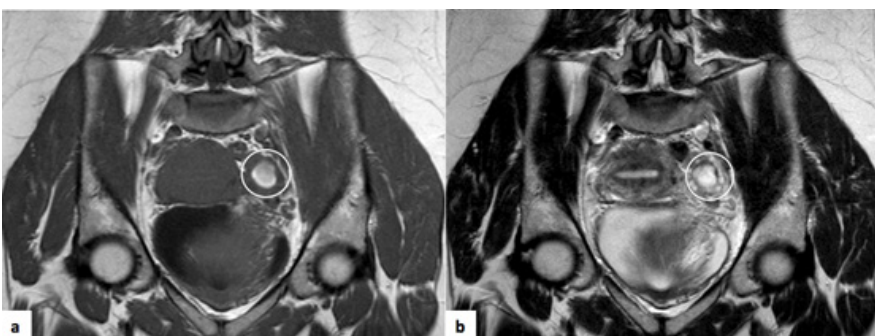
Haemorrhagic cyst. Pelvic MRI of a 33-year-old woman. (a) Coronal T1-weighted image, where it is shown a left adnexal lesion with spontaneous hypersignal (circle). (b) Coronal T2-weighted image where this lesion also shows hypersignal. This is the most typical behaviour of haemorrhagic cysts on MRI.
